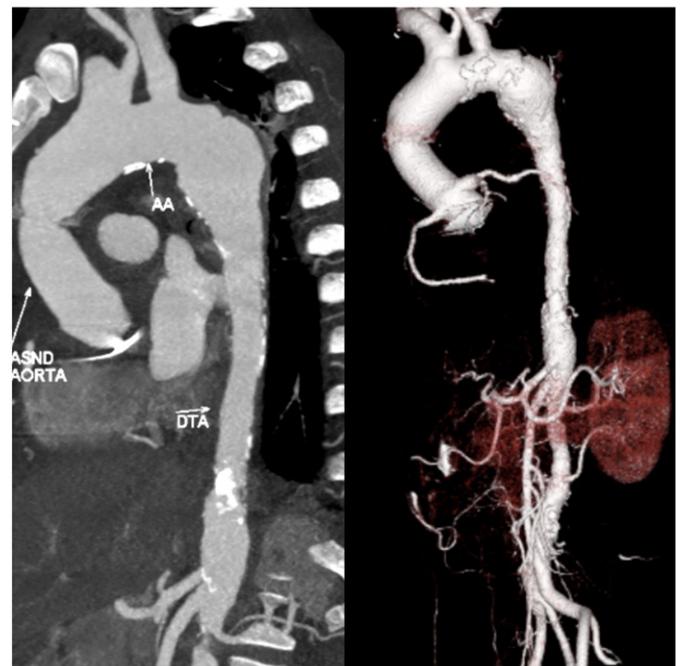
Post-operative CT scan.
